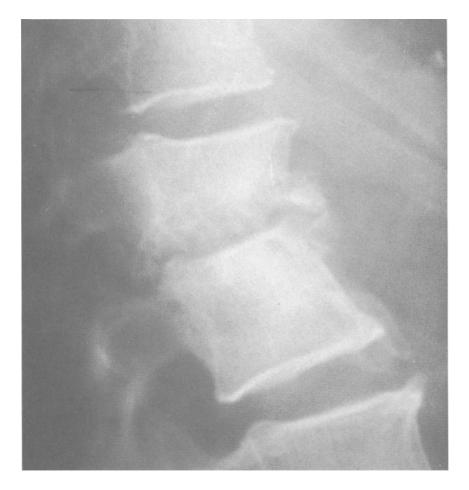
Tuberculous lumbar spondylitis. X-ray showing involvement of two adjacent vertebrae with some collapse. Radiograph courtesy of Maimonides Medical Center Radiography Department.
